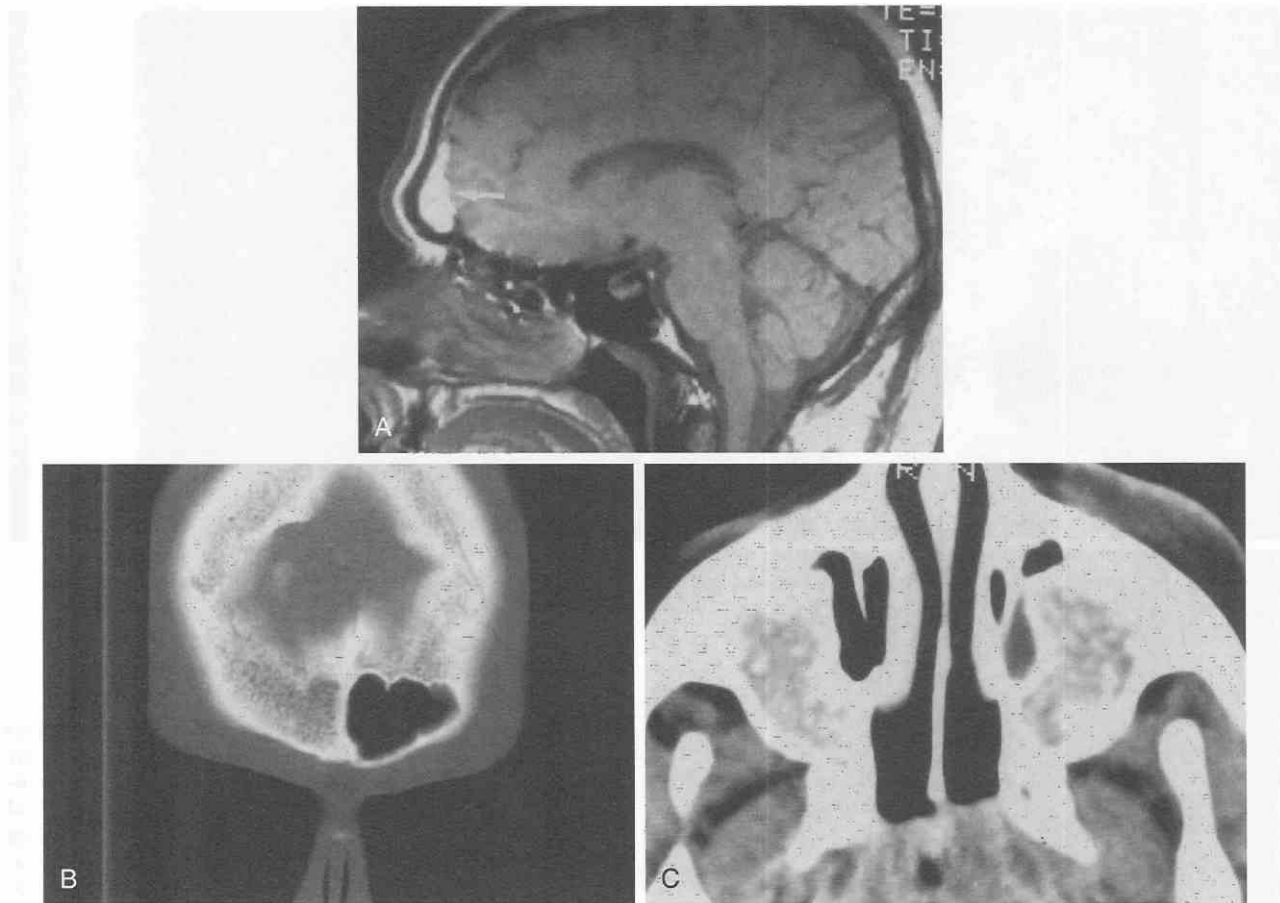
Imposters. *A*, Sagittal T1-weighted (TR500, TE32) image in the midline. Increased signal is seen overlying the frontal sinus (arrow). This may represent fat, hemorrhage, or a paramagnetic substance in a metastatic tumor such as a melanoma. The accompanying coronal CT image (*B*) shows a nonpneumatized and nondeveloped right frontal sinus. The marrow signal from this right frontal sinus was thought to produce the abnormal signal on the MRI study in *A*. *C*, Non-contrast-enhanced axial CT scan through the maxillary sinuses in a patient with sickle cell disease. The speckled pattern overlying the maxillary sinuses proved to be hyperactive marrow within the maxillary sinuses.
